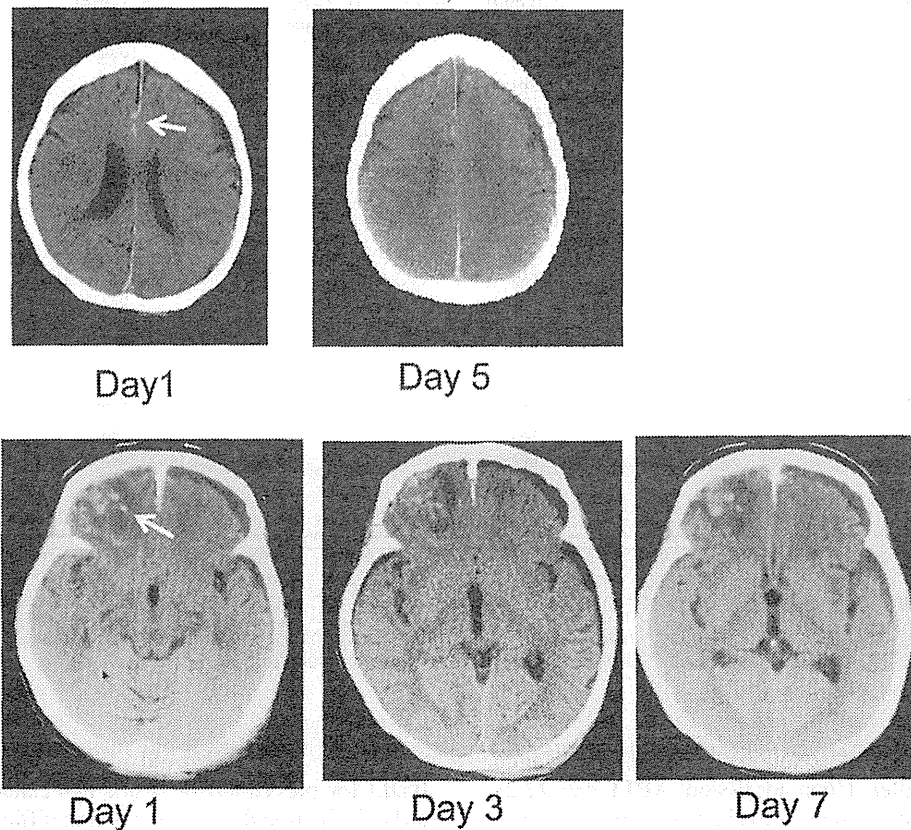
Head computed tomography of an 87-year-old woman (case 6): (Upper) traumatic subarachnoid hemorrhage on days 1 (arrow) and 5; (Lower) head contusion on days 1 (arrow), 3 and 7.
